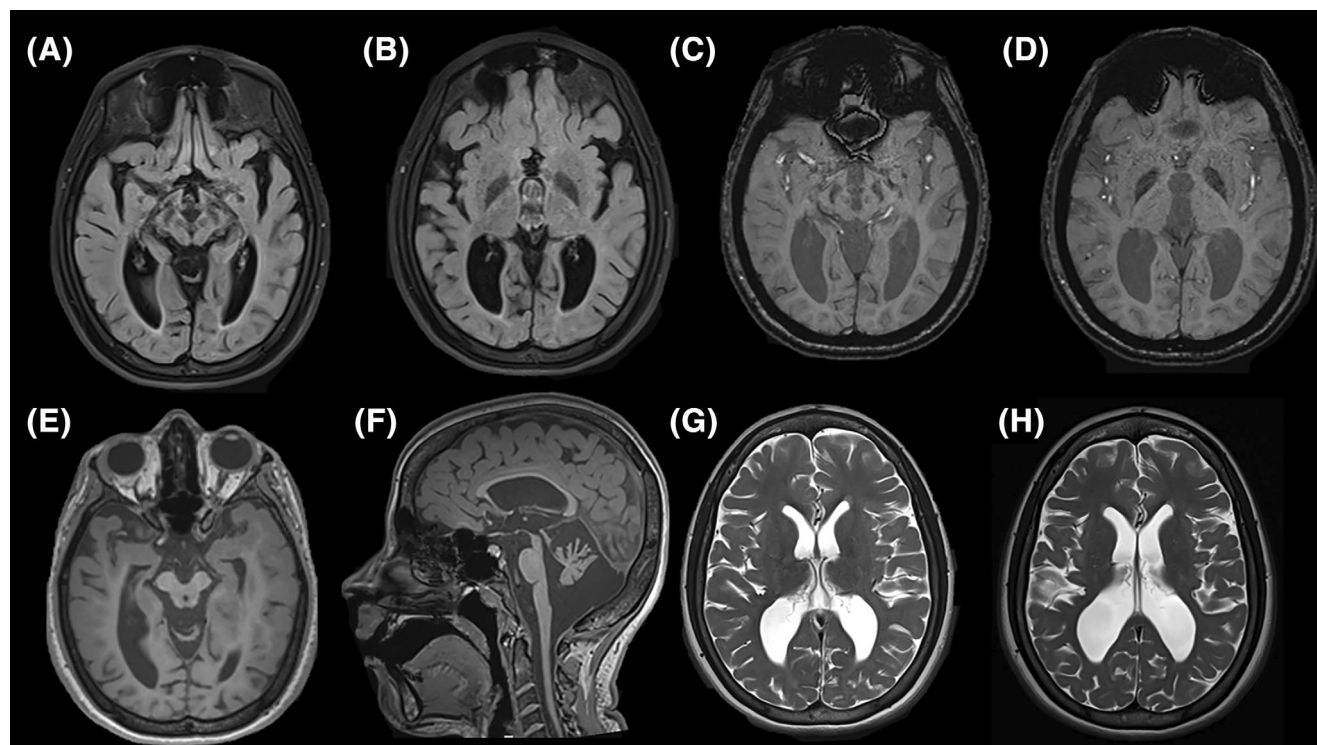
Brain MRI (magnetic resonance imaging) showing red nuclei, substantia nigra, and globi pallidi hypointensity on (A, B) T2-weighted and (C, D) susceptibility-weighted images, medulla, midbrain, and cerebellar atrophy on (E, F) T1-weighted images and progressive cortical atrophy with gradual enlargement of the perisylvian subarachnoid spaces and lateral ventricles in serial MRI scans (G: 13 years, H: 18 years, T2-weighted images).
